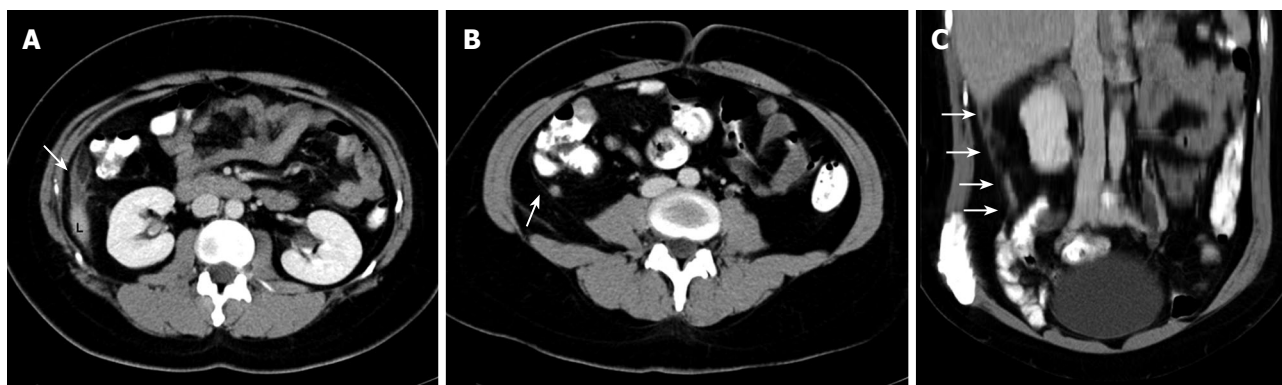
A 30-year-old woman presenting with a clinical diagnosis of acute cholecystitis. A and B: Contrast-enhanced computed tomography (CT) sections showing inflammatory changes (arrow) adjacent to the inferior tip of the liver (L); B: Thickened appendix (arrow) with mild inflammatory changes in the retrocecal region; C: Coronal reconstruction showing the extent of inflammatory changes (arrows) from the retrocecal region to the tip of the liver.
